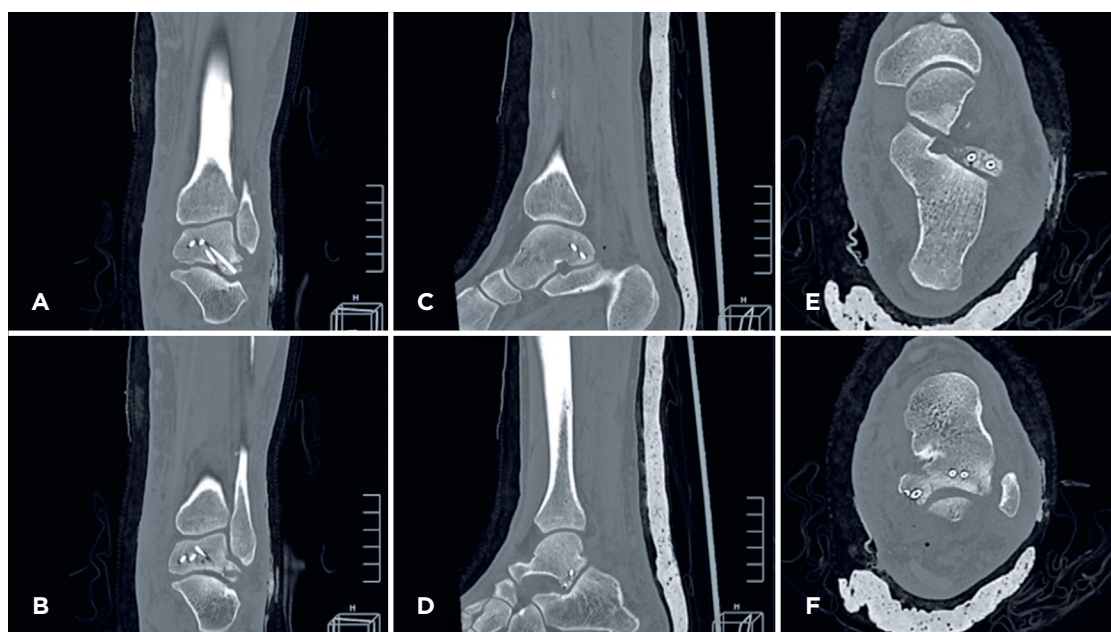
Postoperative computed tomography scan of the ankle obtained on the following day. (A, B) Coronal sections showing anatomical fixation of the lateral process of the talus. (C) Sagittal section demonstrating reduction with screws in the medial tubercle (Cedell). (D) Stable fixation of the lateral process. (E) Axial section showing reduction without joint stepoff and adequate fixation of the lateral process. (F) Anatomical reduction of the posterolateral tubercle of the talus (Shepherd).
